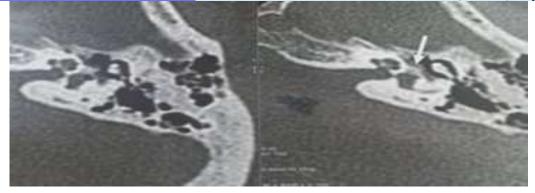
Axial CB-CT reconstruction images of the left petrous bone shows increase density at the footplate of the stapes at the region of oval window (white arrow).
